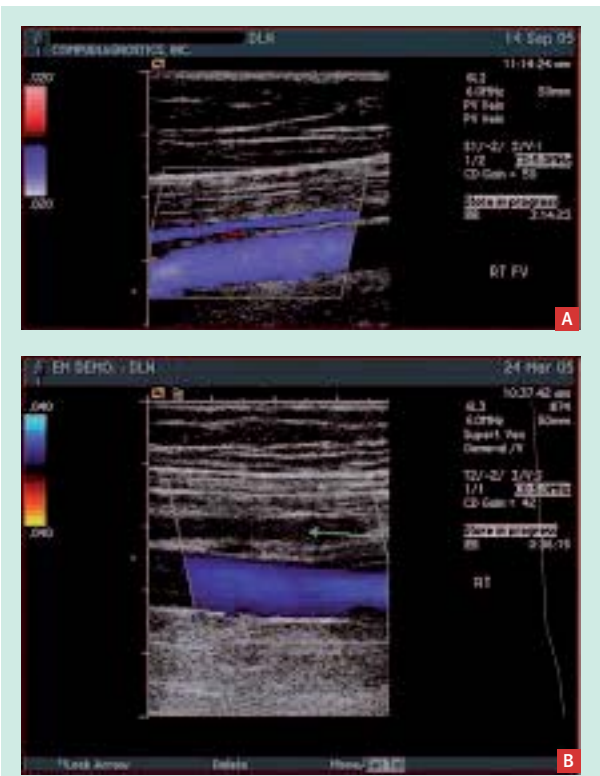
a: color Doppler showing antegrade flow in duplicated femoral vein segment
